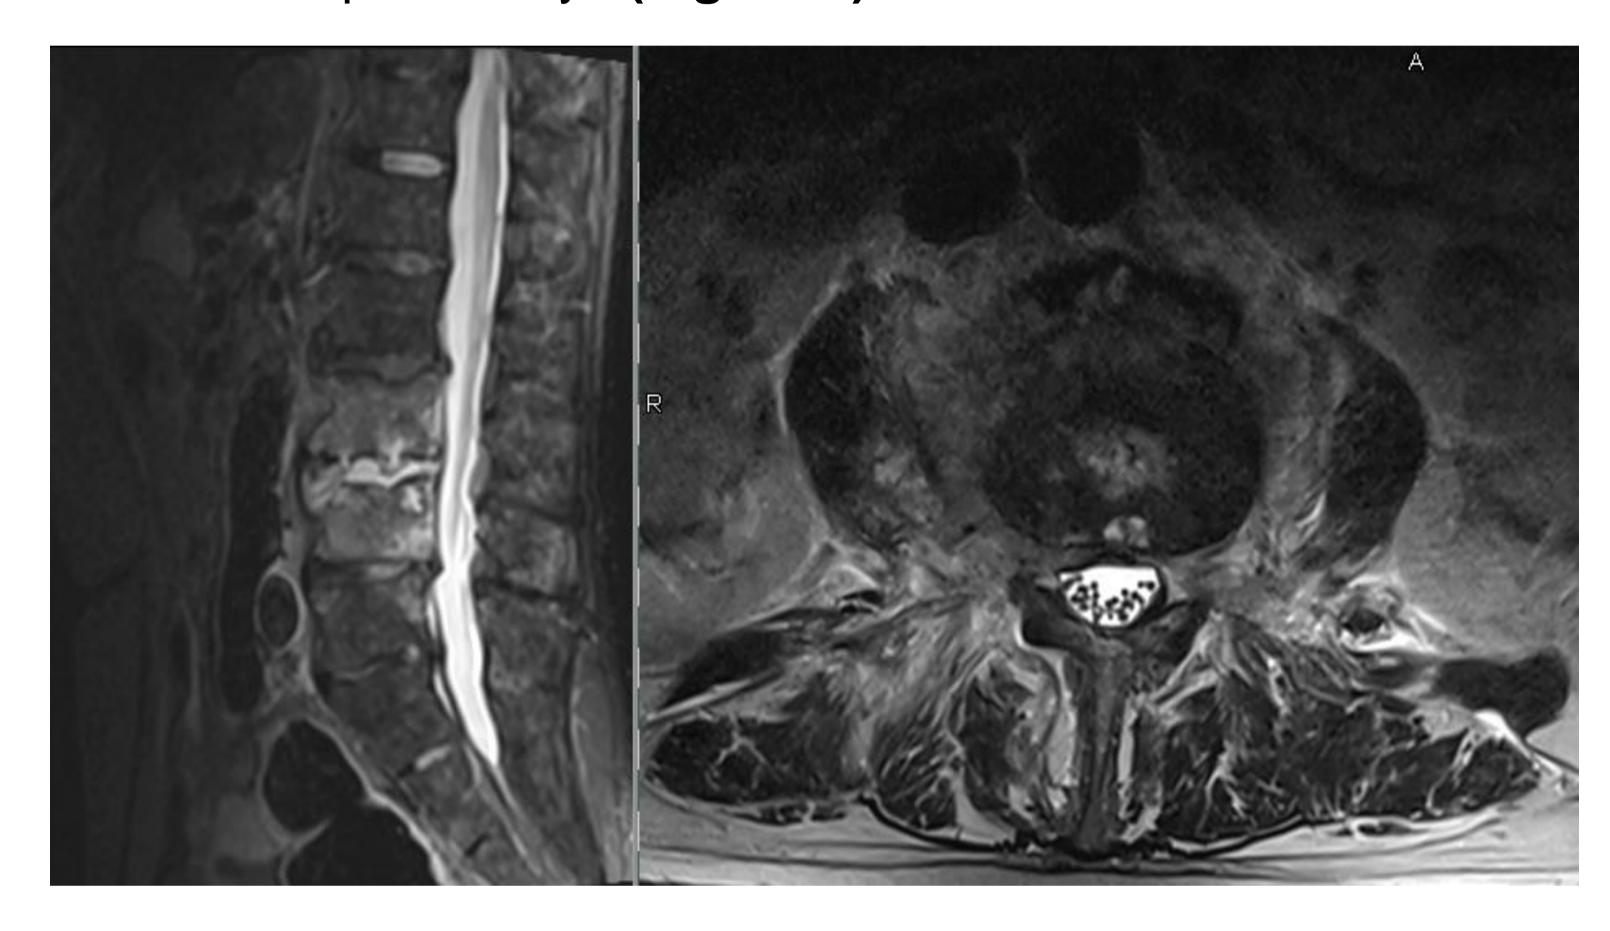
MRI: advanced spondylodiscitis L3/4 with fluid signal in the disc and two abscesses in the right Psoas major muscle
